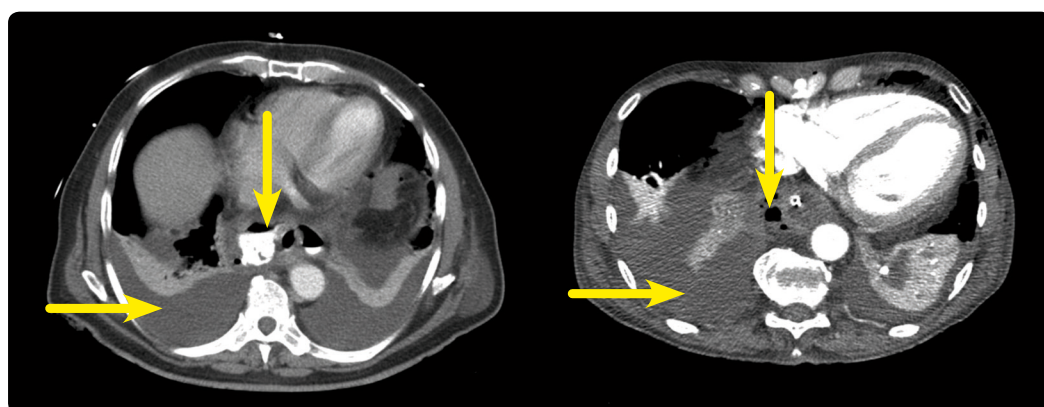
CT scan with oral and intravenous contrast showing IAAL findings: extravasation of contrast material through the anastomosis or a stapler line, adjacent collection, free intra-abdominal liquid, pleural effusion and free intra-abdominal gas.
